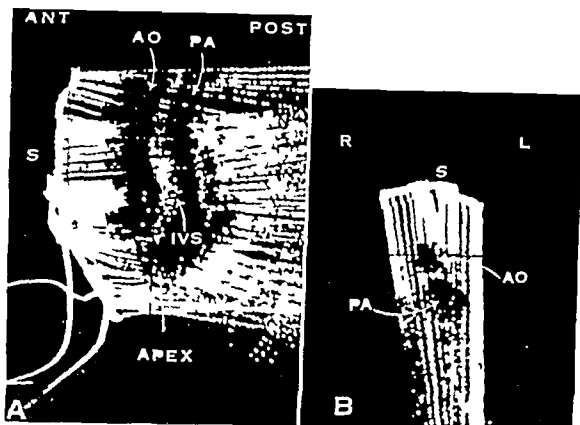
A long axis cross section of a patient with transposition of the great arteries. The ventricular outflow tracts and arterial trunks appear parallel. The interventricular septum (IVS) does not cross the upper portion of the anterior ventricle to produce an oval cross section of its outflow tract. B transverse cross section of the same patient along the left third intercostal space showing a slightly left anterior position of the anterior aorta. Abbreviations ANT anterior POST posterior Ao aorta PA pulmonary artery S skin R right and L left. From King Steeg and Ellis. Demonstration of transposition of the great arteries by cardiac ultrasonography. Radiology 107:181, 1973. By kind permission of Radiology and Dr King.
